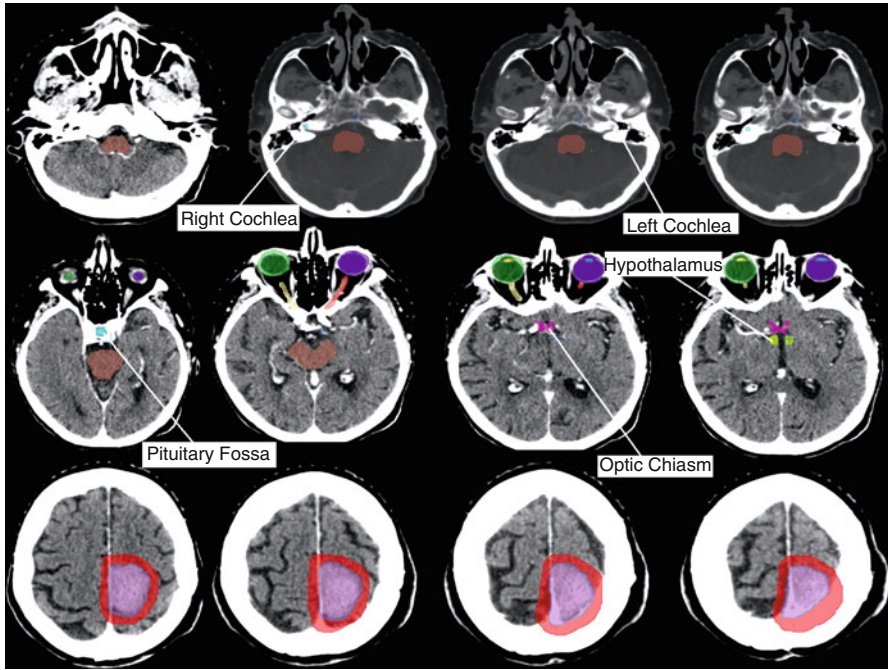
Parasagittal meningioma and critical structures contoured on planning CT
